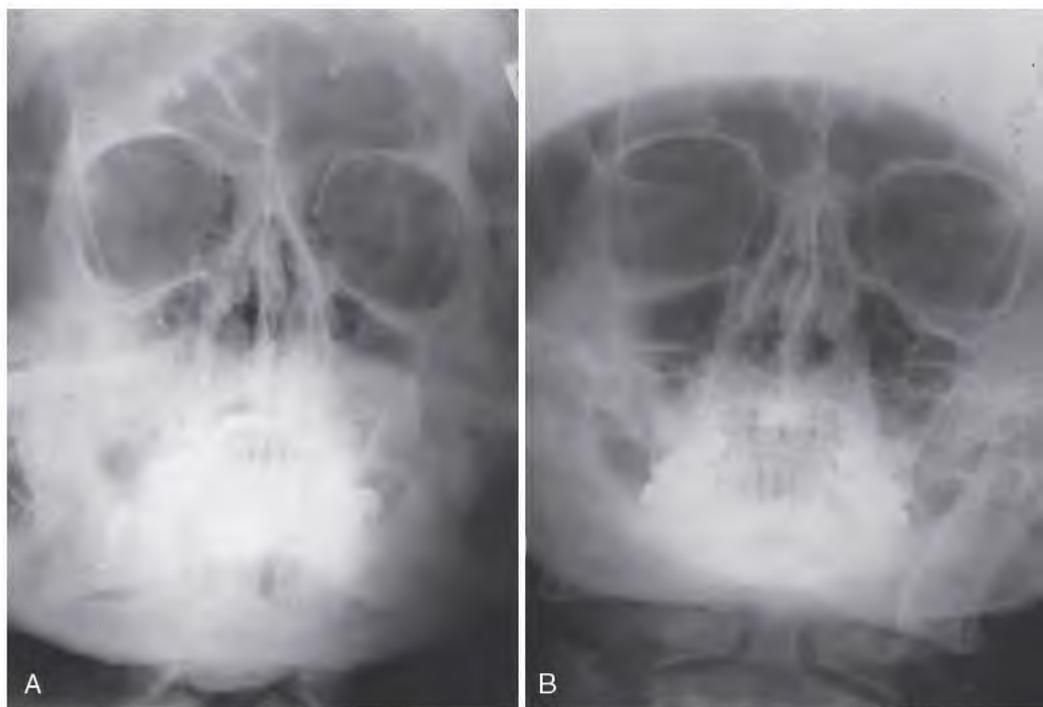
A, Infections, empyema, and inflammation of the maxillary sinuses can accompany implant surgery. If the diagnosis is questionable, a Waters' view can be taken using a standard 70 kV 15 ma dental x-ray machine and a high-speed 8×10 -inch cassette with intensifying screens. The patient's chin is placed on the cassette with the nose raised about 2 cm from it and the tube at 0 degrees aimed through the head directly at the midface. The resulting x-ray film shows a cloudy antrum. B, After appropriate treatment, the antrum appears clear bilaterally.
